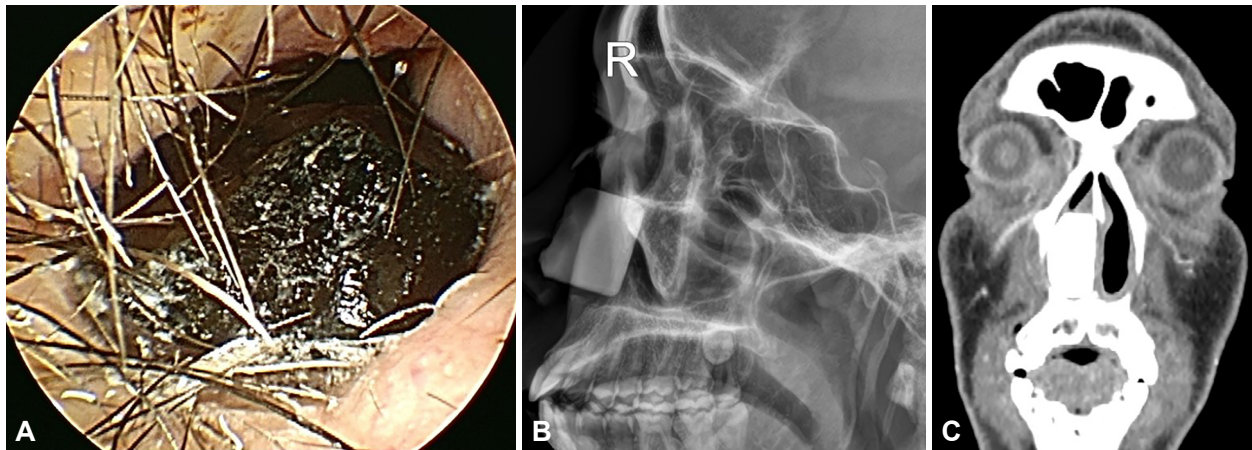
Endoscopic and imaging findings of the foreign body before surgery. A: Nasal endoscopy showing a dark-colored hard material that totally obstructed the patient's right nasal cavity. B: Lateral paranasal sinus (PNS) X-ray demonstrating a foreign body measuring approximately 2.5 cm×2.3 cm in the right anterior nasal cavity. C: Coronal PNS computed tomography demonstrating high-density foreign body measuring 2.7 cm×2.2 cm×1.6 cm.
